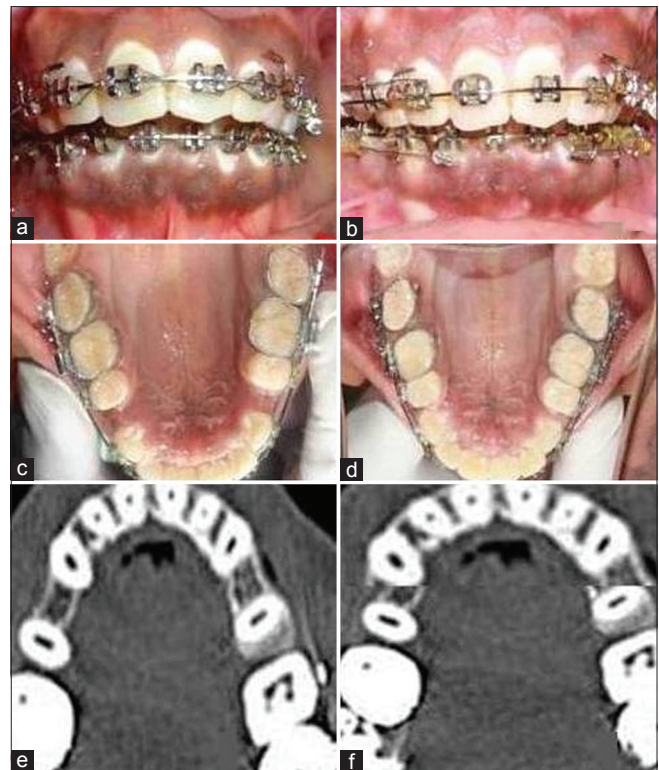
(a) Preoperative frontal, (b) postoperative frontal after 6 months, (c) preoperative palatal, (d) postoperative palatal after 6 months, (e) preoperative computed tomography, (f) postoperative computed tomography after 6 months
